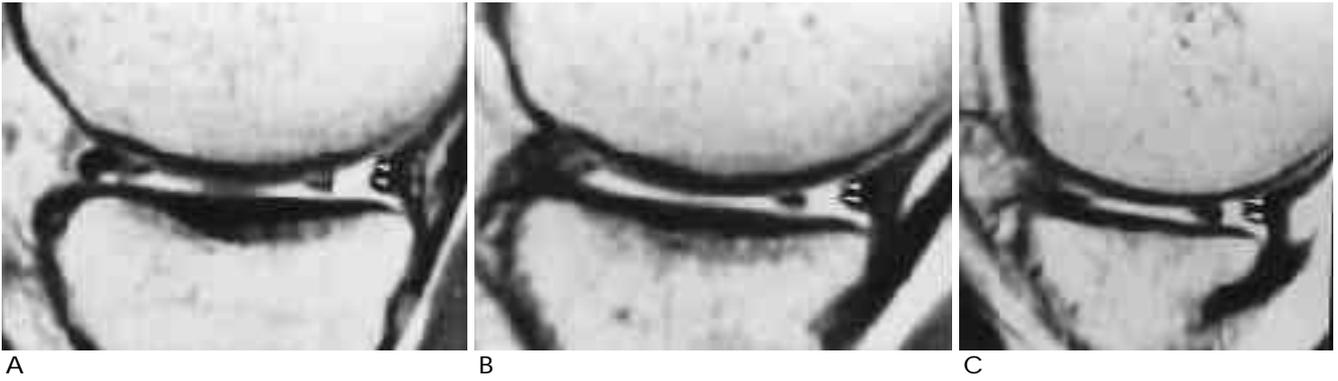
Sagittal proton density-weighted fast SE MR images (TR/TE, 2600msec/16msec) of left knee in a 20-year-old man with longitudinal tear of posterior horn of the medial meniscus. Vertical high signal intensity band of tear (arrowheads) is equidistant from periphery to the free margin on consecutive images (A-C: lateral to medial direction).
